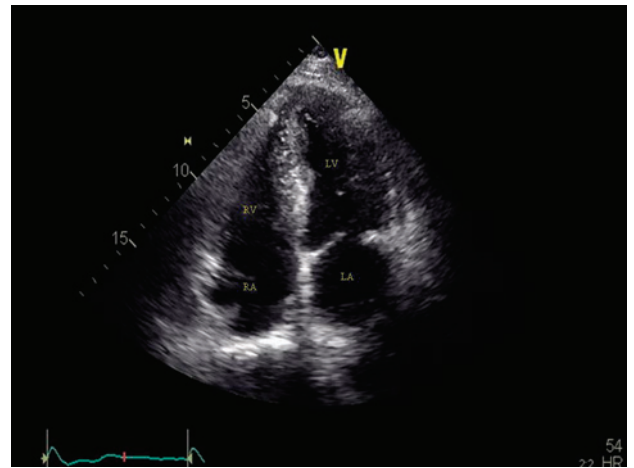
Transthoracic echocardiographic image of all 4 cardiac chambers.
